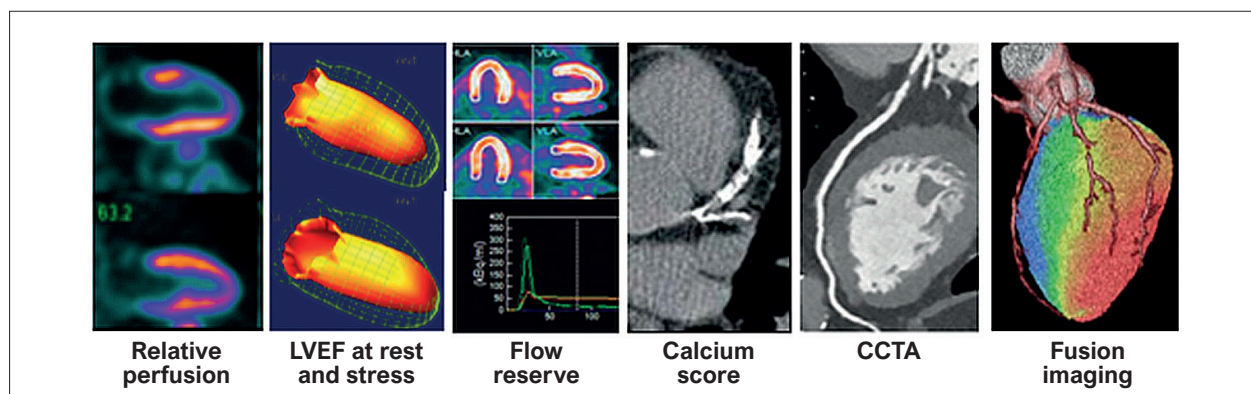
PET/CT perfusion imaging: comprehensive information. CCTA: coronary computed tomography angiography; LVEF: left ventricular ejection fraction; PET/CT: positron emission tomography/computed tomography. Adapted Cheng et al.²¹
